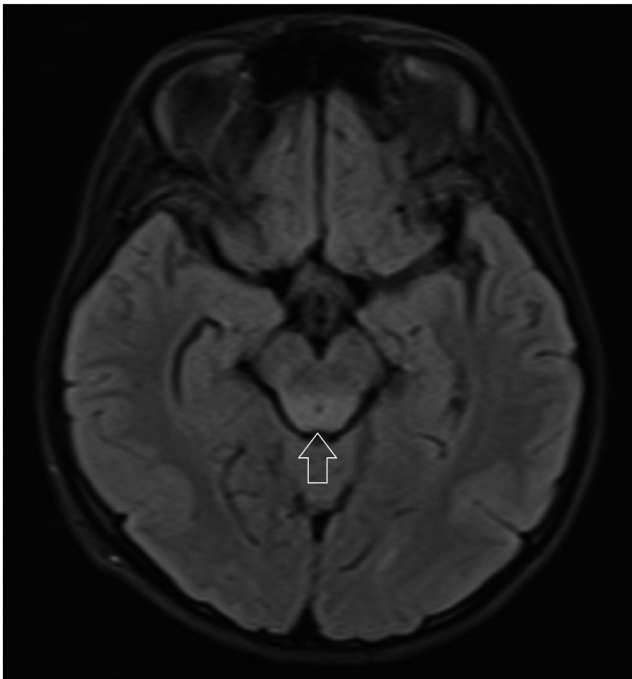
FLAIR MRI image of the patient showing hyperintensity in dorsal midbrain (white arrow)
